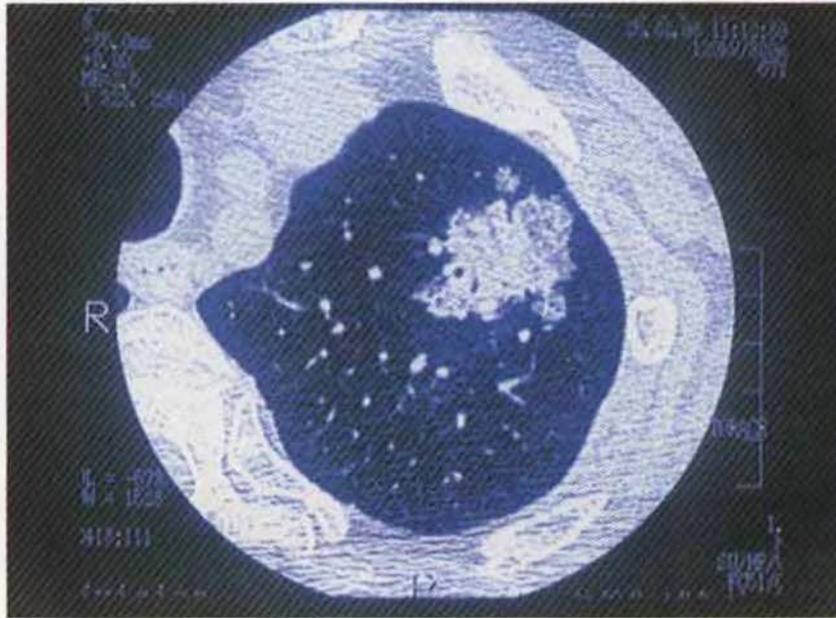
HRCT: a core of alveolar opacification surrounded by ground glass attenuation and a crazy paving in the upper right lobe (BAC, nonmucinous subtype)
